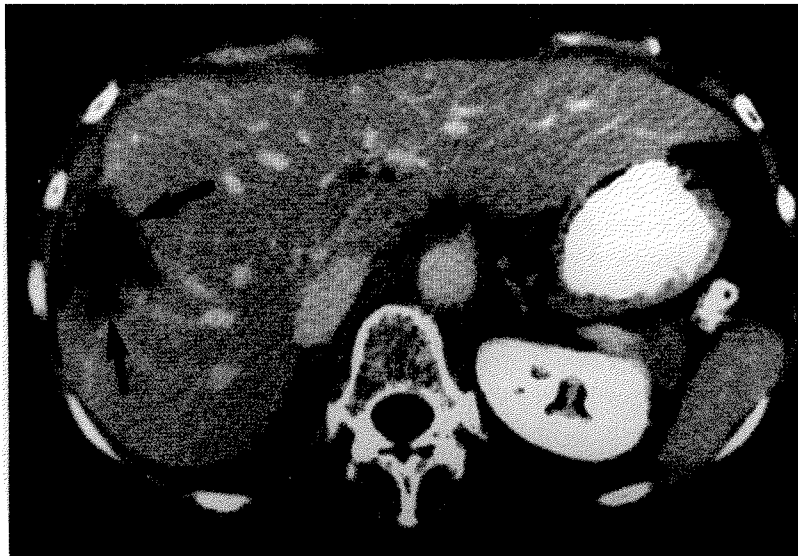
Follow-up CT scan one year after embolization with almost complete resolution of hematoma and small low density residual area (arrows).
